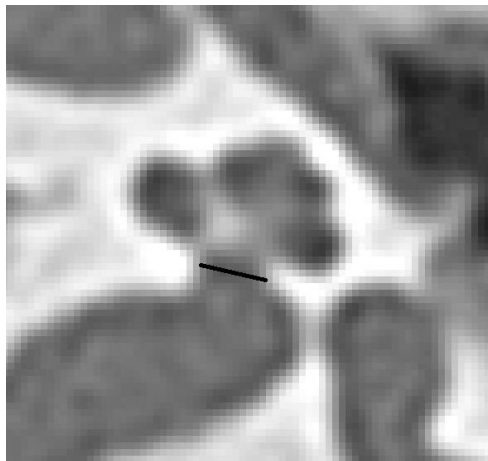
CT scan of a cochlea indicating the width of the BCNC with a black line.
